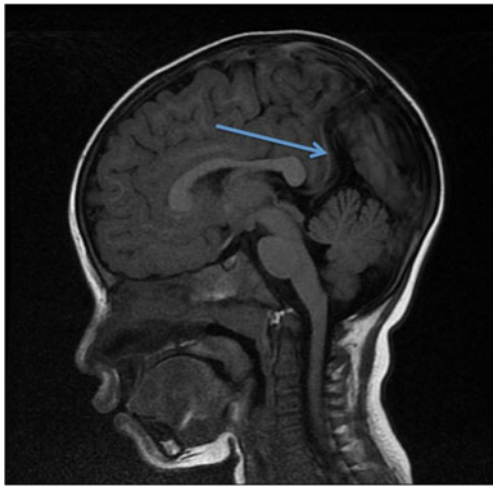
MRI of a 16-year-old female patient presenting with seizures. Note the vertically oriented persistent fetal vein
